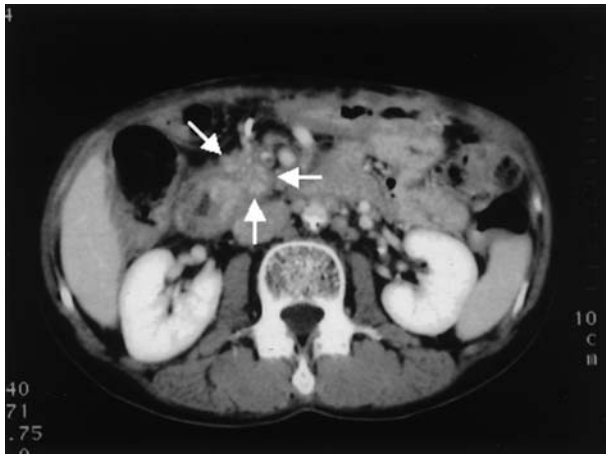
CT scan of patient 9, taken 2 months after the post-treatment examinations, shows a reduction in tumor size (*arrows*)
